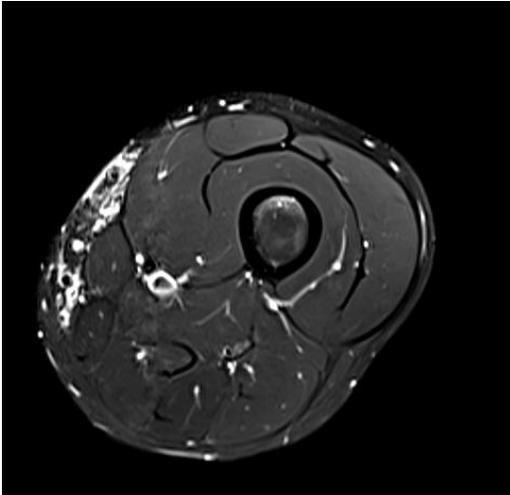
The young child in the Fig 11 clinical picture – corresponding STIR axial and coronal MRI images shows a microcystic LM with STIR hyperintensities in the skin and subcutaneous tissues of the medial thigh.
